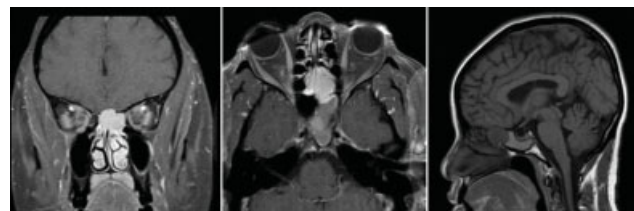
Magnetic resonance imaging demonstrating contrast enhancement (part A & B) and ethmoid involvement.
